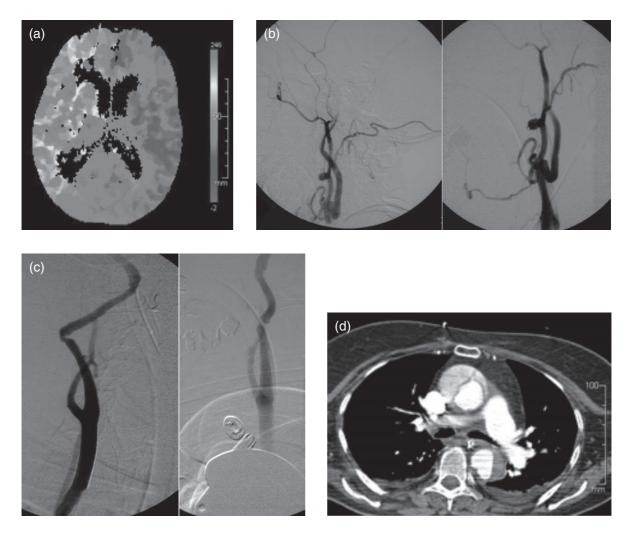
(a) CT perfusion image shows severe hypoperfusion of the right hemisphere. (b) Initial angiogram reveals filling of the ECA before the ICA (*left* and *right*: lateral views, at higher magnification on the right). (c) Angiographic images (*left*, oblique projection; *right*, AP projection) show improved flow after deployment of overlapping Wallstents[™] (Boston Scientific/Schneider, Minneapolis, MN). (d) CT angiogram demonstrating an aortic dissection.
